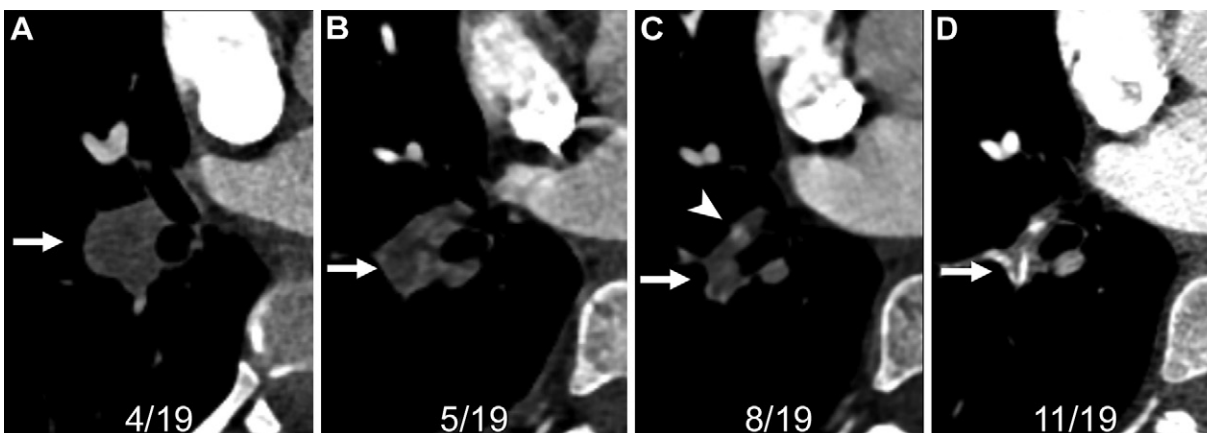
Evolution of thrombus from acute to chronic on axial images from CTPA in a 44-year-old woman. (A) Image from the initial CT study in April 2019—when the patient presented to the emergency department with chest pain—shows an expansile thrombus (arrow) in the right lower lobe basal trunk. The patient started anticoagulation therapy and underwent repeat CTPA owing to a repeat episode of chest pain; the repeat CTPA showed no acute pulmonary embolism. (B) Image from the repeat CTPA in May 2019 shows reduced extent and contraction of the thrombus (arrow). Follow-up CTPA was performed owing to continued symptoms. (C) Image from the follow-up CTPA in August 2019 shows further contraction and organization of the thrombus (arrow) with early recanalization (arrowhead). Note that the caliber of the pulmonary artery itself has also decreased. (D) Image from follow-up CTPA in November 2019 shows further recanalization (arrow) of the chronic thrombus.
